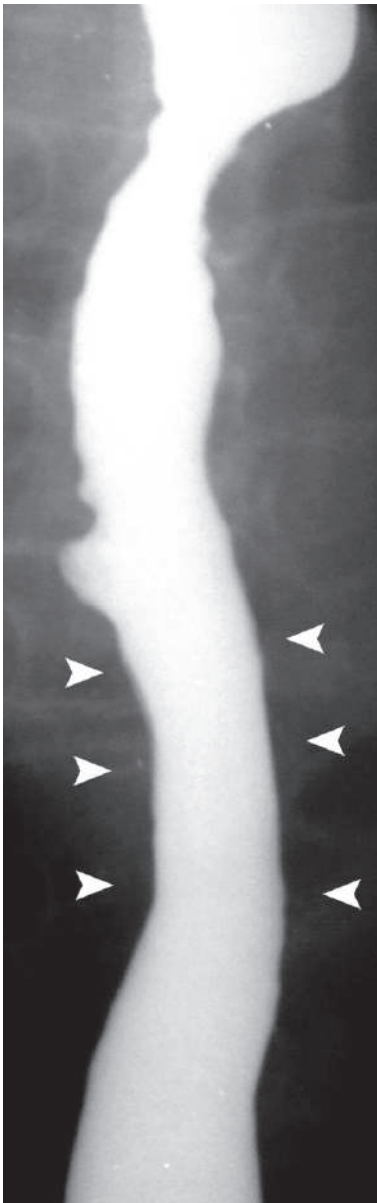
Anteroposterior barium swallow radiograph of the esophagus in a patient with scleroderma shows poor esophageal motility (*arrowheads*)
